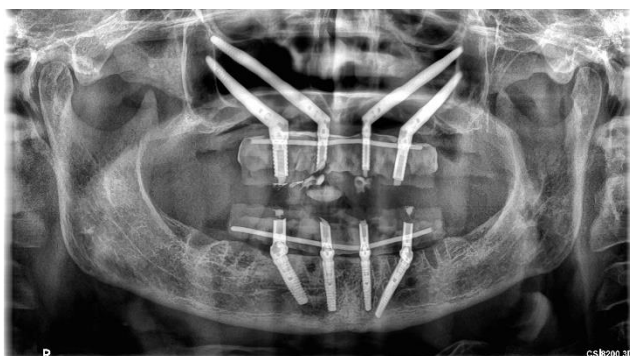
X-ray at 12-month follow-up.*
